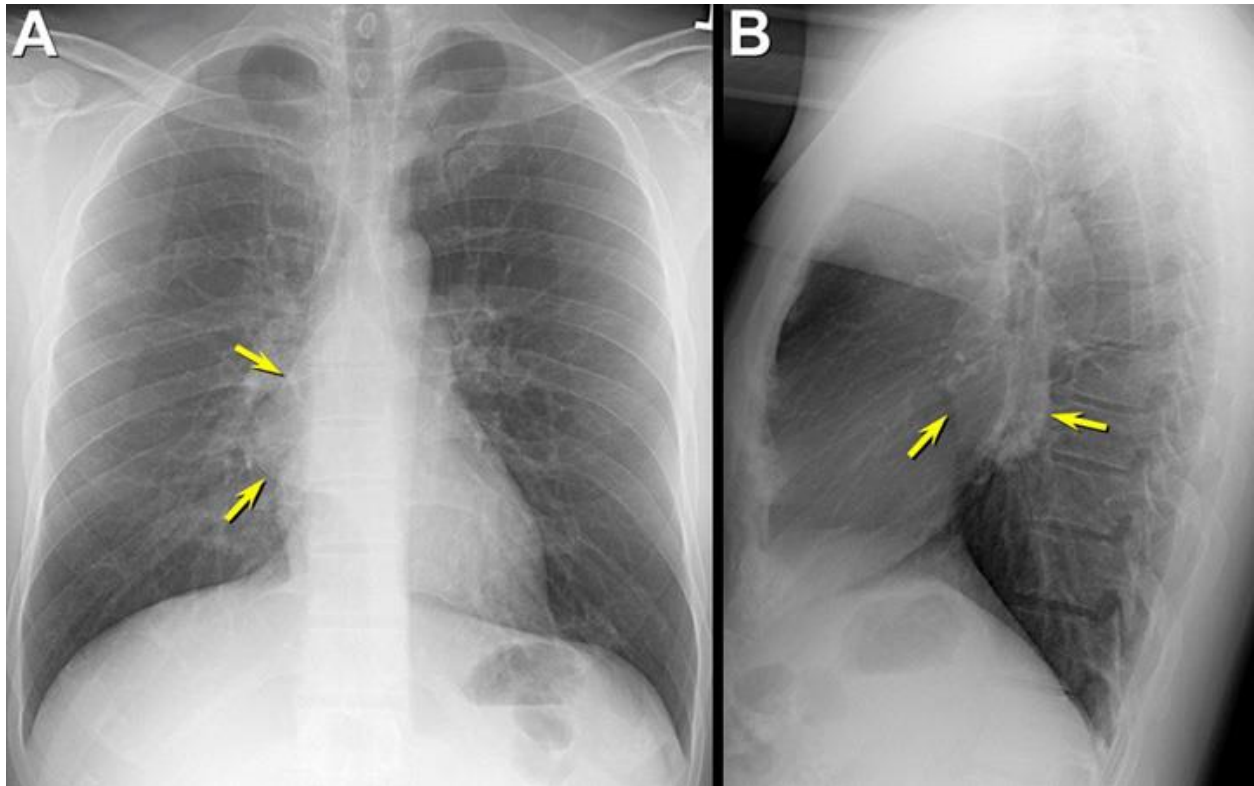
Frontal (A) and lateral (B) chest radiography shows an abnormal mediastinal contour creating a convex “bulge” in the azygosoesophageal recess (arrows, A). The abnormal mediastinal contour is clearly visible in the infrahilar window region on the lateral chest radiograph (arrows, B).
